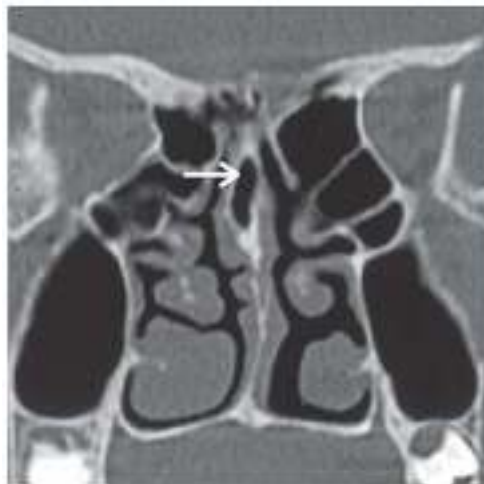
CT PNS in Coronal plane showing Pneumatized septum.³⁴
